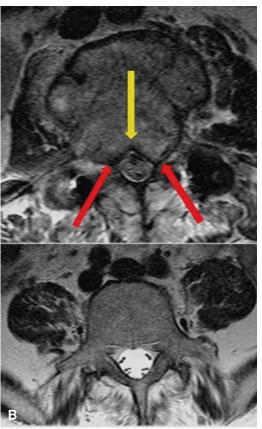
Multiple myeloma. *A*: Sagittal, CT scan of thoracolumbar vertebrae of a patient with multiple myeloma shows punched-out lytic lesion of T10 (*closed arrows*), and vertebra plana of L4 with preserved disc spaces (*open arrows*). *B*: Draped curtain sign. Axial, T2W MR image (*upper row*) in a different patient at the level of a lumber vertebral body shows a plasmacytoma with posteriorly extending soft tissue mass (*red arrows*) that protrudes into the anterior epidural space on both sides of the firmly attaching posterior longitudinal ligament (*yellow arrow*), thereby producing the characteristic "draped curtain" appearance. Upper image shows the draped curtain appearance. Lower image shows an unaffected lumbar vertebra for comparison.
